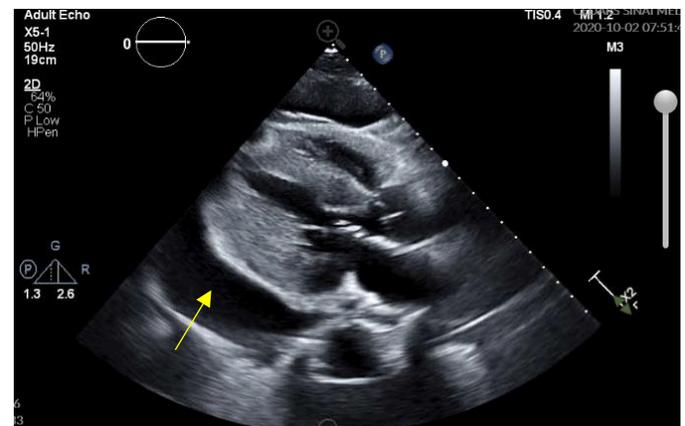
Echocardiogram parasternal long axis view demonstrating presence of large pericardial effusion (yellow arrow)
